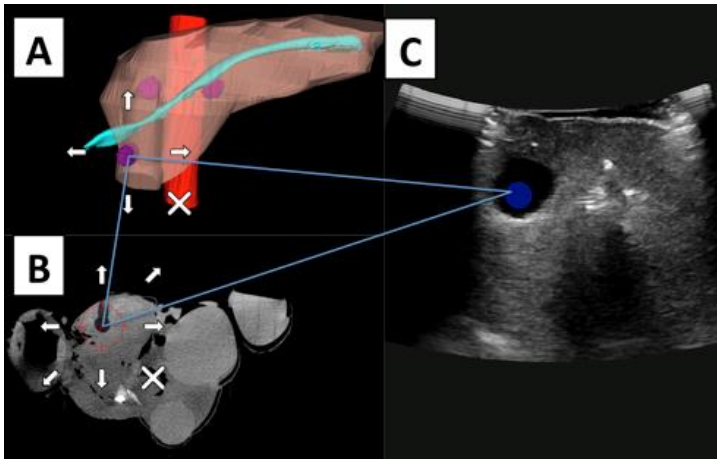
Ultrasound based registration with an intraparenchymal landmark, in this case a pancreatic tumor. A. Depicts the segmented CT image, where the tumor in the processus uncinatus is selected. After identifying the same tumor on the ultrasound image (C), the corresponding structure is identified on the CT image (B).*
